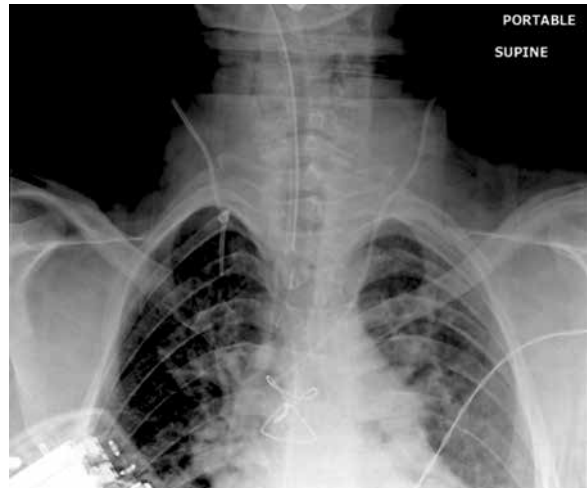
Chest X-Ray with the knotted PAC in situ
